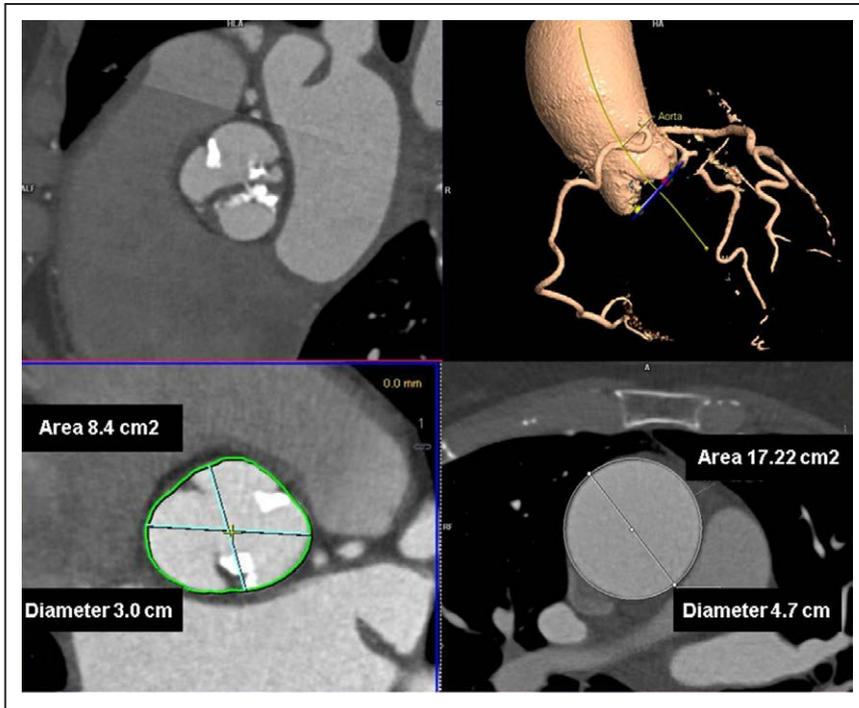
A contrast-enhanced computed tomographic scan in a female patient (height, 1.65 m) with a bicuspid aortic valve and dilated ascending aorta. Top left represents a multiplanar reformatted short-axis view of the bicuspid aortic valve. Bottom left represents multiplanar reformatted short-axis view of the aortic root with diameter and area measurements. Top right represents volume-rendered image with centerline reconstruction (yellow line) demonstrating the thoracic aorta, with a dilated ascending aorta. Bottom right represents multiplanar reformatted short-axis view of ascending aorta with diameter and area measurements. The ratio of aortic area/height is 10.42 cm²/m.
